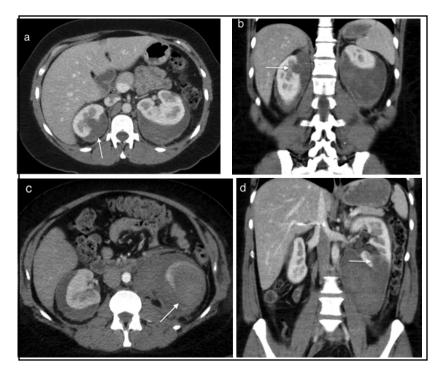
An abdomen/pelvis CT scan was performed after the patient represented to the emergency department two days after discharge with symptoms of nausea, vomiting, severe abdominal pain radiating to the left flank, weakness, and a hemoglobin drop from 10.0 g/dL on discharge to 8.4 g/dL on readmission. Imaging revealed interval development of a right-sided subcapsular hematoma extending from the previously visualized right renal lesion (a, b) and interval increased size of the large left renal mass (c, d), now measuring approximately 5.2 cm AP x 3.7 cm TV x 5.3 cm CC, with interval increase in associated retroperitoneal hematoma now measuring 27 cm in CC dimension. The patient was subsequently taken to interventional radiology for possible embolization; however, renal arteriography did not reveal a hypervascular lesion or active extravasation.
